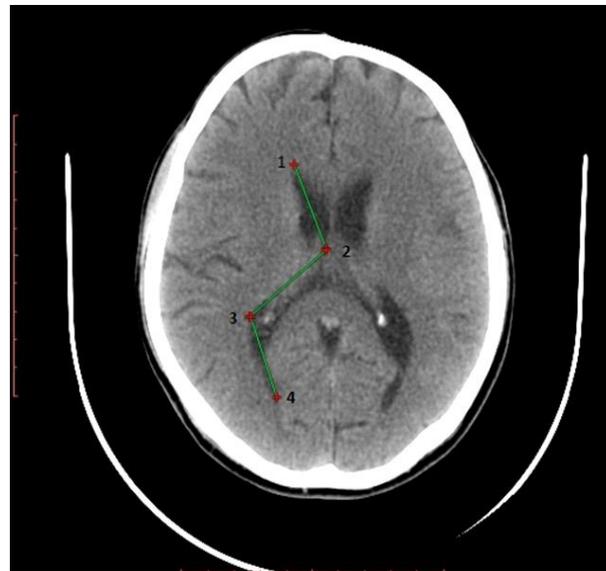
CT scan at the level of interventricular foramen showing parts of lateral ventricle
